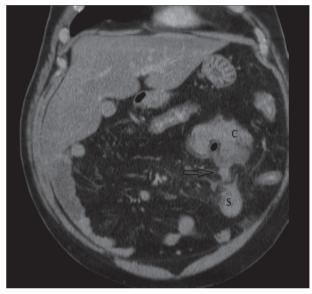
Intestinal malrotation and left-sided acute appendicitis in computed tomography coronal section. C : Cecum, S : Sigmoid colon. Left-sided inflamed appendix and pericaecal inflammatory changes (arrow).
